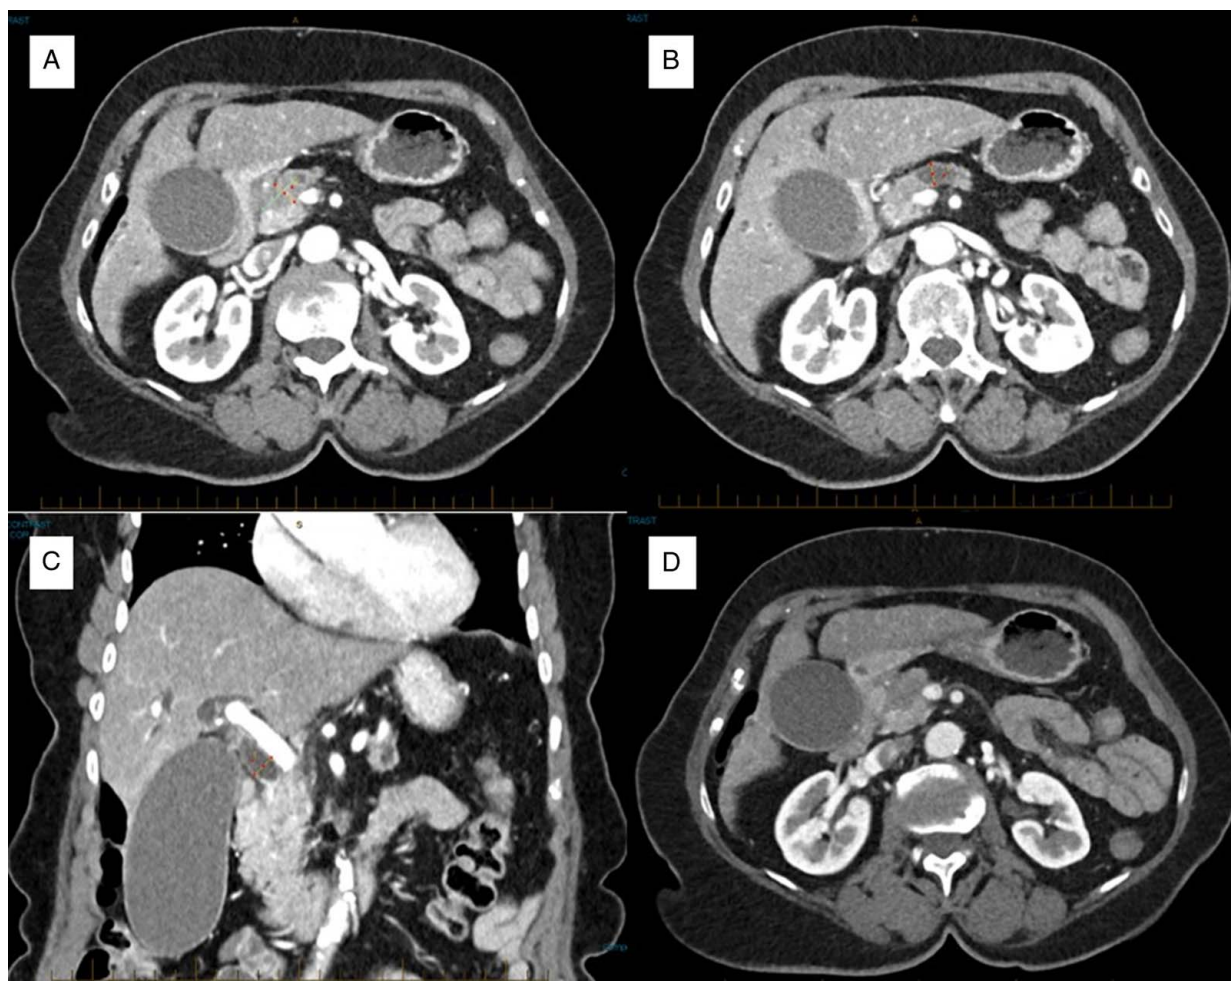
Case 1—Contrast-enhanced CT images demonstrating a pancreatic head mass measuring 21×13 mm (A) with SMV contact <180 degrees (D). The MPD was 10 mm, and (B) the CBD measured at 12 mm (C). CT indicates computed tomography; SMV, superior mesenteric vein.
